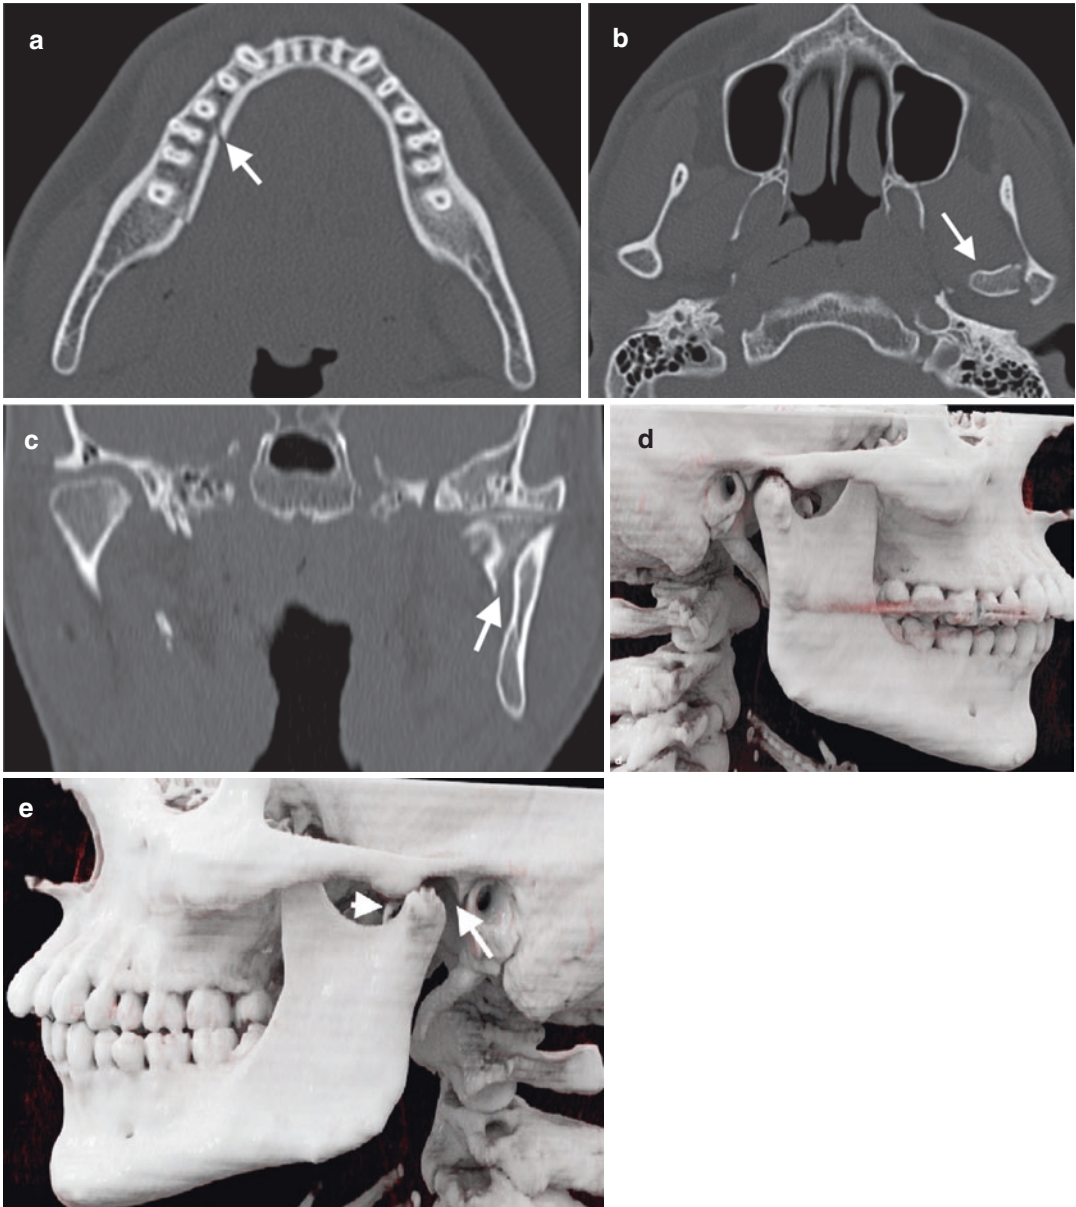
Complex mandible fracture. (a) Axial CT image reveals a linear right mandible corpus fracture (arrow). Axial (b) and coronal (c) CT image of the same patient demonstrates left condylar fracture (arrows). (d) CR
